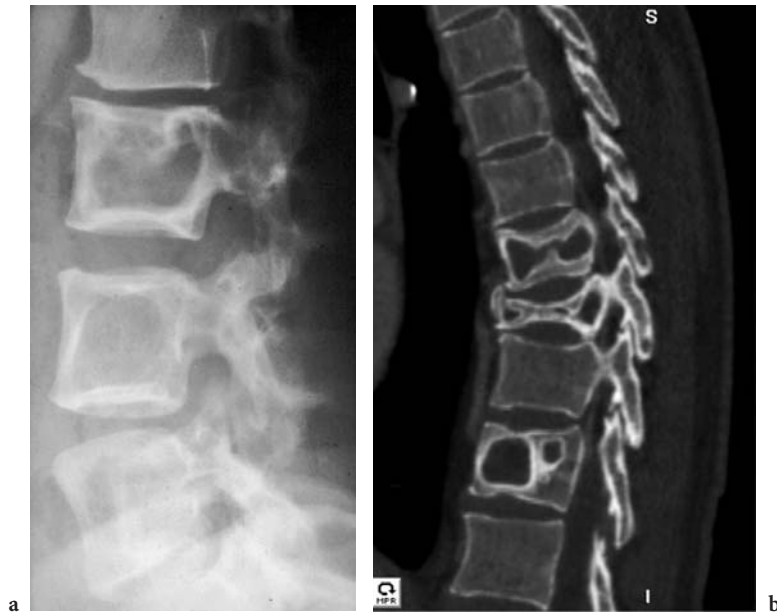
Polyostotic fibrous dysplasia. Well-defined non-expansile osteolytic lesions with a thin sclerotic rim in several lumbar vertebral bodies in a case of spinal fibrous dysplasia (a). Sagittal reformatted CT in a different case of polyostotic fibrous dysplasia (b).
